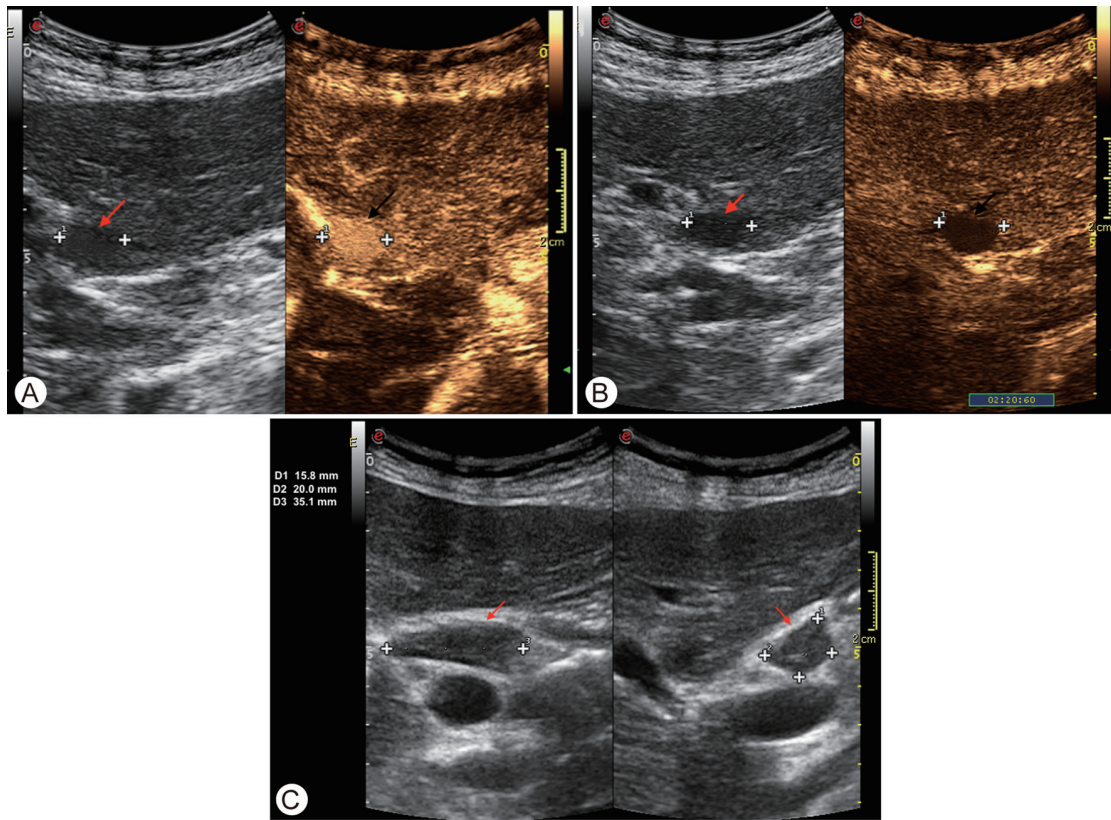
CEUS features of the HCC nodule at segment II (CEUS LI-RADS LR5). (A) CEUS arterial phase showing hyperenhancement of the nodule. (B) CEUS late phase showing wash-out of the nodule. (C) Hilar metastatic lymphadenopathy (20 mm x 35 mm). CEUS, contrast-enhanced ultrasound; HCC, hepatocellular carcinoma.
